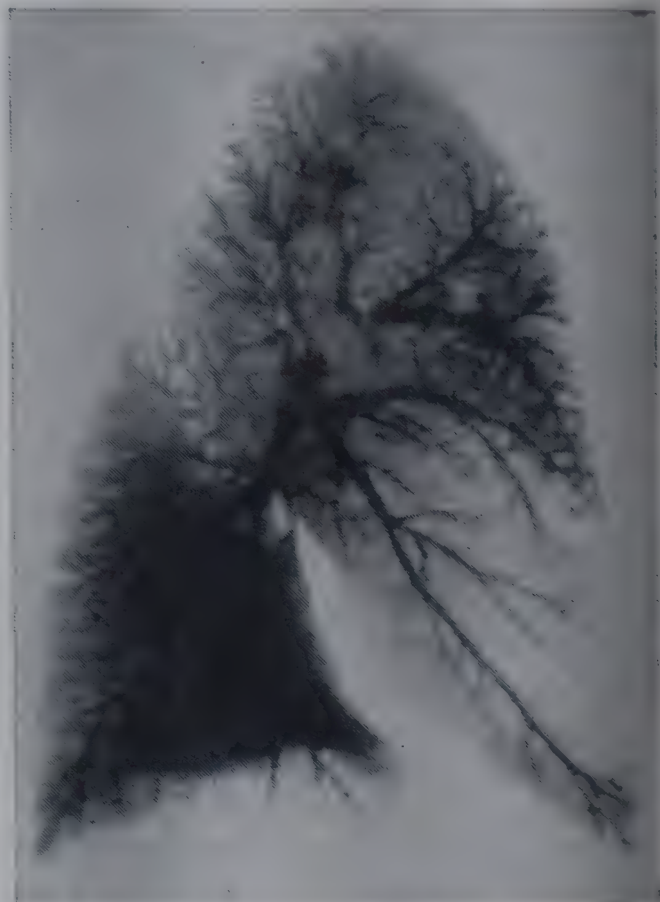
X-ray photograph of lung (injected with barium) from a case of lobar pneumonia (after Gross). *Upper right hand area.* Consolidated area—red hepatization. The main vessels are constricted and the fine vascular structure is less dense than in the normal lung. *Lower right hand area.* Consolidated area—gray hepatization. The main vessels are patent but the fine vessels have been occluded. *Lower left hand area.* Healthy portion of lung except for compensatory congestion; the vessels are dilated.
